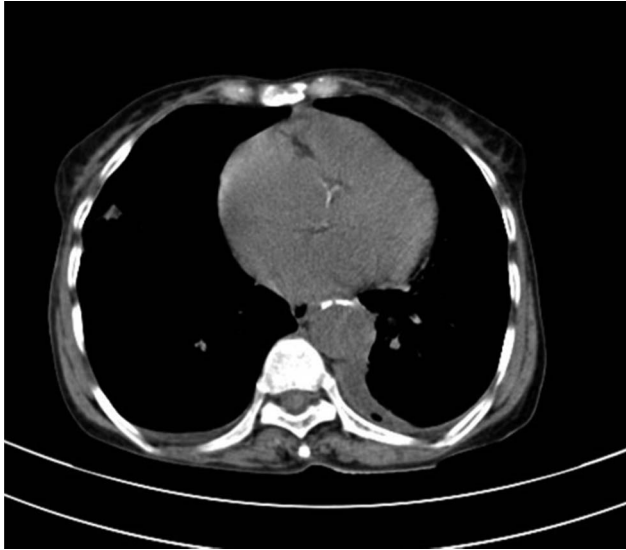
contrast enhanced computed tomography chest showing near total resolution of empyema with re-expansion of lungs.
